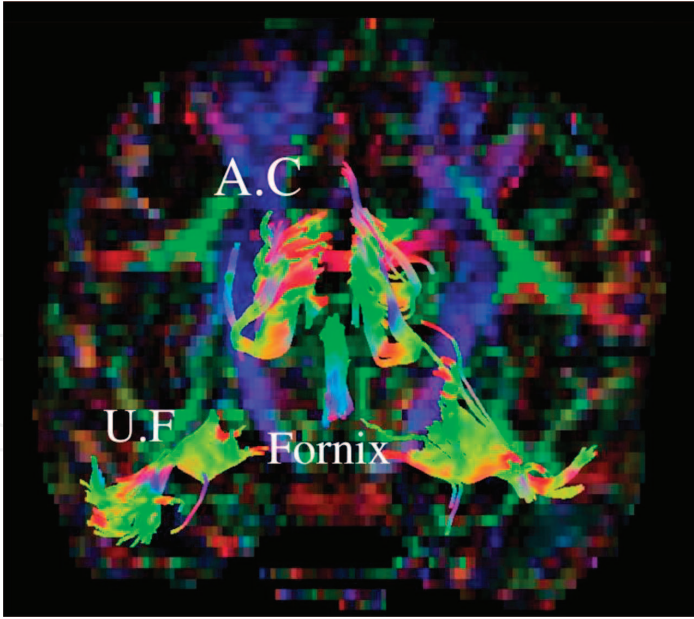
MRI tractography in coronal view showing anterior cingulate (A.C) fibers, fornix and uncinate fasciculus (U.F) fibers.
